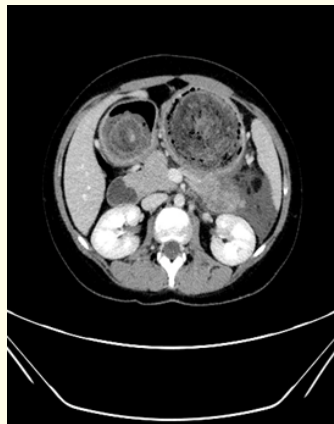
CT abdomen transverse.
